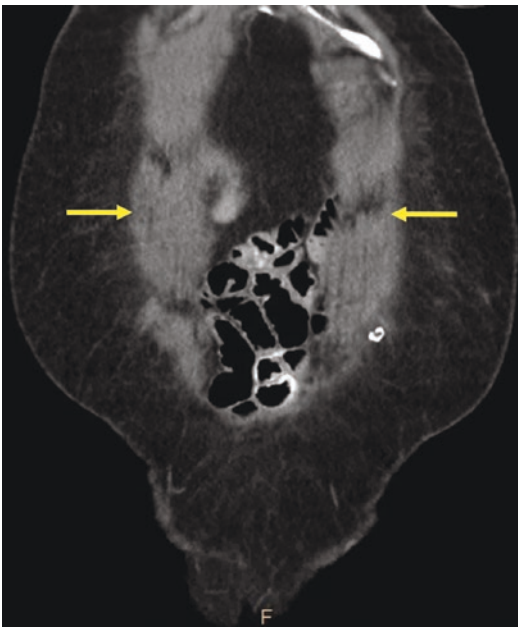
CT abdomen in the same patient in the sagittal plane showing a splaying of the rectus abdominis muscles (yellow arrows)
